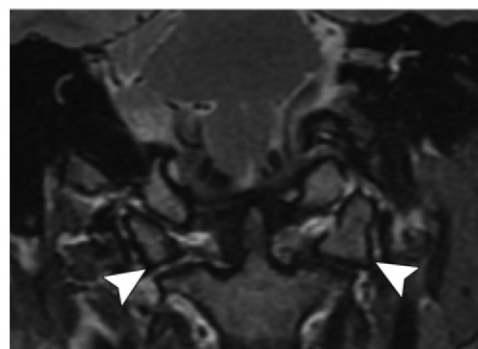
Burst fracture of the atlas. (a) Axial CT image shows a burst fracture involving the anterior arch of C1 with displacement (arrow) of the fracture fragments. (b) Axial T2-weighted MR image shows disruption (arrow) of the transverse ligament. (c) Coronal T2-weighted MR image shows splaying of the lateral masses of C1 (arrowheads), consistent with a burst fracture.
